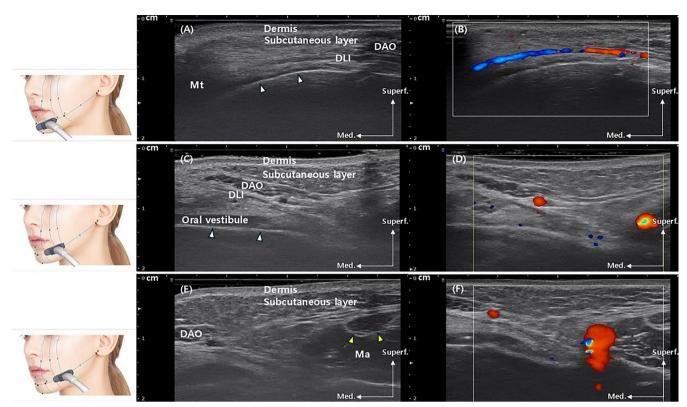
Ultrasonographic images of adjacent structures of the buccomandibular space at three landmark points (I, II, III) in the lower third of the face described in Figure 1 (15 MHz linear transducer, scale unit: cm). (A) Ultrasonographic image at the anterior landmark point of the lower third of the face, point I. (B) Doppler image of the horizontal labiomental artery at the anterior landmark, point II. (C) Ultrasonographic image at the middle landmark, point II. (E) Ultrasonographic image at the posterior landmark, point III. (F) Doppler image of the facial artery at the posterior landmark, point III. The buccal cortex of the mandibular body is marked with white arrowheads in ultrasonographic images at the anterior and the middle landmark points. The tendon of the masseter muscle is marked with yellow arrowheads in the ultrasonographic image at the posterior landmark point. DAO, depressor anguli oris muscle; DLI, depressor labii inferioris muscle; Ma, masseter muscle; Mt, mentalis muscle.
